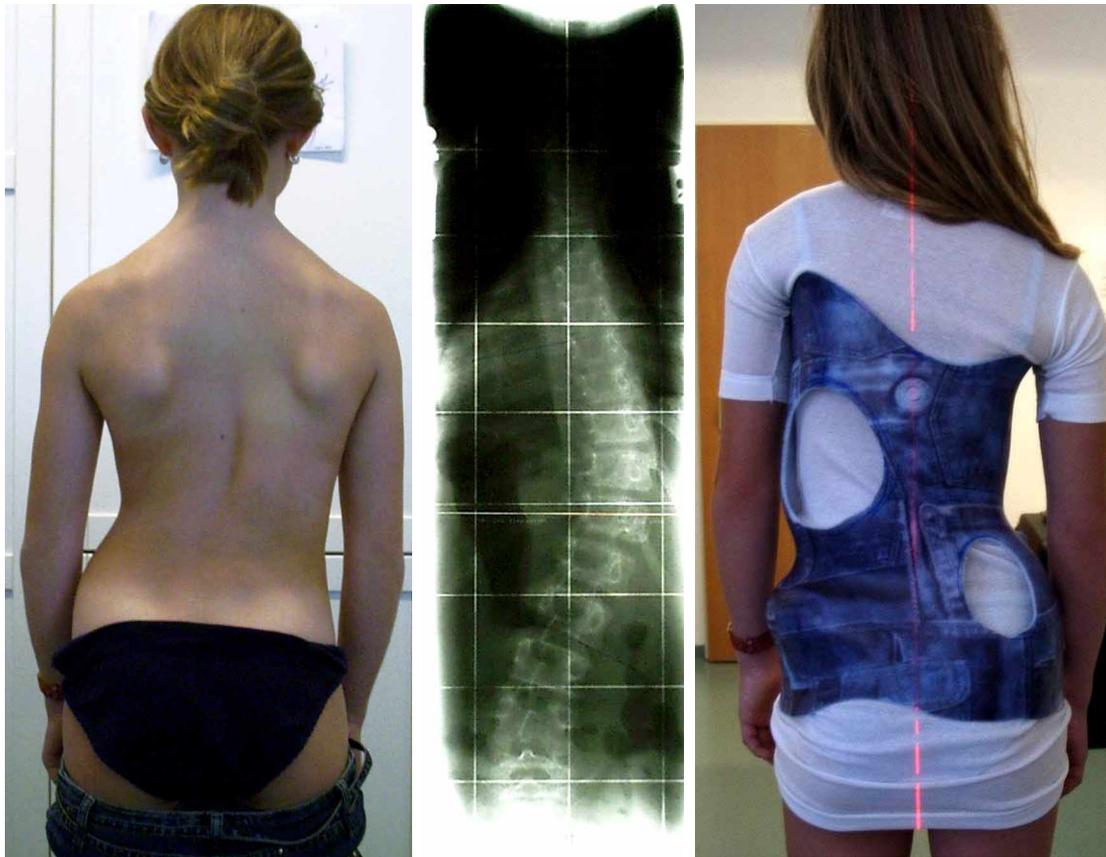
Patient with a low thoracic curvature and a clear imbalance with a decompensation to the right. The X-ray of this patient shows the apical vertebra at Th 10/11. Right: in the RSC-brace the imbalance seems to mirror the clinical picture on the left, while C7 is centred (red line). Pelvic prominence clinically to the left, in the brace to the right.
